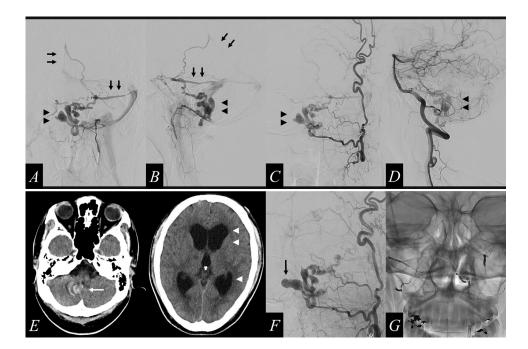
Digital subtraction angiography (DSA) shows a dural arteriovenous fistula (DAVF), which is fed by the jugular branch and hypoglossal branch of the left ascending pharyngeal artery (A and B), the jugular branch of the left occipital artery (C), and the posterior meningeal artery from the left vertebral artery (D) that drains into the straight sinus and the left superior petrosal sinus (A, B; arrows) through the vein of the lateral recess of the fourth ventricle, which is dilated and tortuous with large varices (A-D, arrowheads). 28 days after the initial bleeding event, the CT image shows a radical increase in the size of the varix (E, white arrow) and severe ventriculomegaly (E, white arrowheads). DSA imaging shows a radical increase in the size of the varix (F, black arrow), compared to its previous size. We performed transarterial coil embolization on the main feeders (G)
